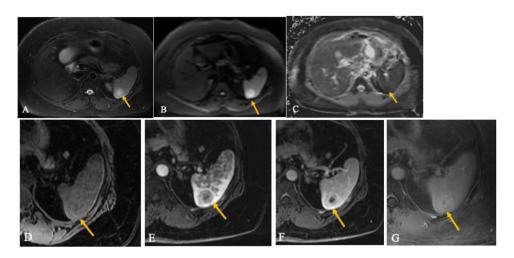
Further evaluation with contrast-enhanced MRI of the abdomen was performed. T1W, T2W, DWI/ADG, and multiphase contrast-enhanced sequences were obtained. (A) Axial T2W sequence with fat saturation. The splenic lesion (yellow arrow) is T2-intermediate to hyperintense. The central T2-hyperintense signal is similar to fluid signal intensity. (B). Axial DWI (B-value 800). (C). Axial ADC map. The lesion shows hyperintensity on DWI with corresponding mild hypointensity on ADC map which confirms restricted diffusion. (D) Axial T1W sequence with fat saturation precontrast. (E) Axial T1W sequence postcontrast arterial phase. (F) Axial T1W sequence postcontrast venous phase. (G) Axial T1W postcontrast delayed phase. The T1-isointense splenic lesion (yellow arrow) demonstrates gradual enhancement peripherally, with nonenhancing central cystic and/or necrotic area. The lesion is hypoenhancing on arterial phase compared to the splenic parenchyma (E) and becomes isoenhancing on delayed phase (G).
